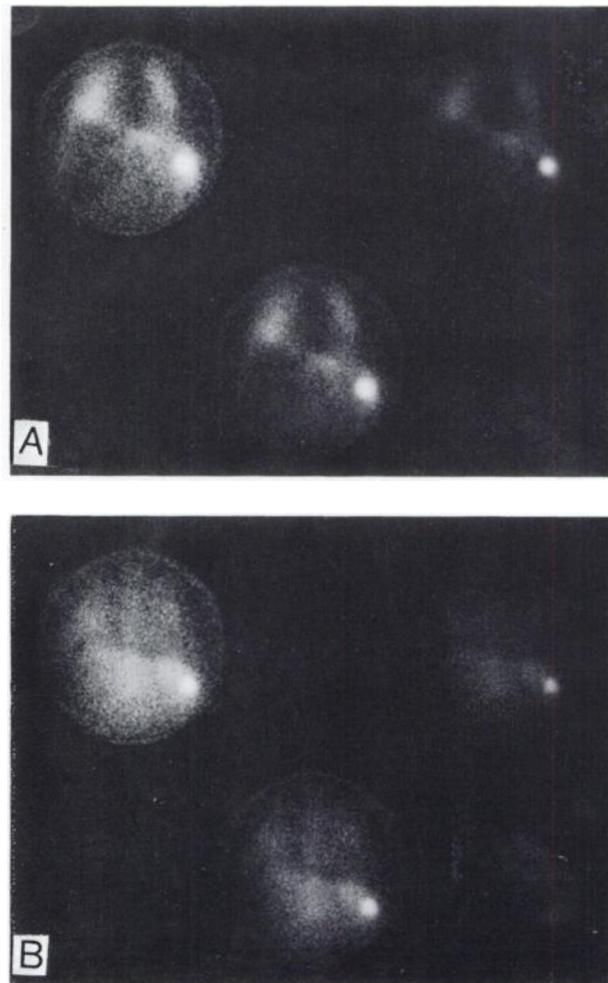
Camera splenoportoscintigram of patient with post-necrotic cirrhosis of liver. A is MAA scintigram (intrasplenic injection); accumulation of tracer is in liver, spleen and lungs. B is ¹⁹⁹Au scintigram (i.v. injection) performed immediately after MAA scintigram using pulse-height discrimination. Two scintigrams can be superimposed, and radioactivity of MAA scan pertaining to liver can be recognized easily.
